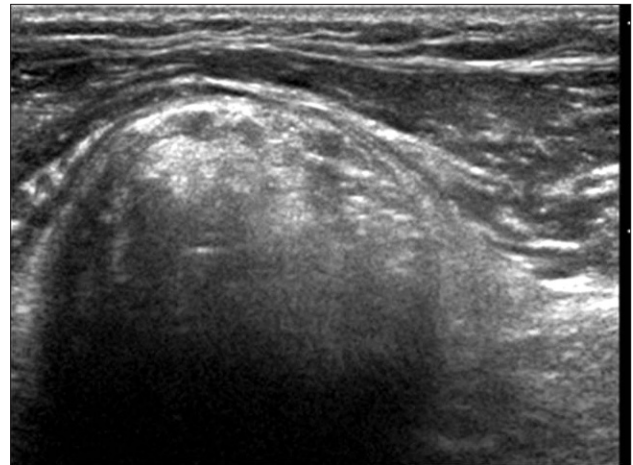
The ultrasound (US) scan of US-guided biopsy reveals a well-defined soft tissue mass and prominent acoustic shadowing caused by internal ossifications.
